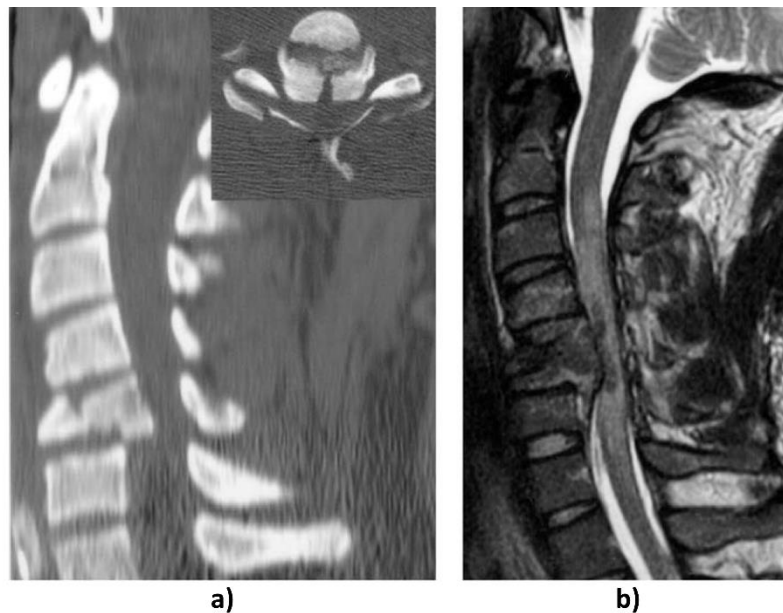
a) CT scan of a C5 burst fracture causing substantial canal compromise. b) The corresponding T2-weighted MRI image shows severe cord compression. Image adapted from Kwon et al. (2006).¹Hyperextension injuries
